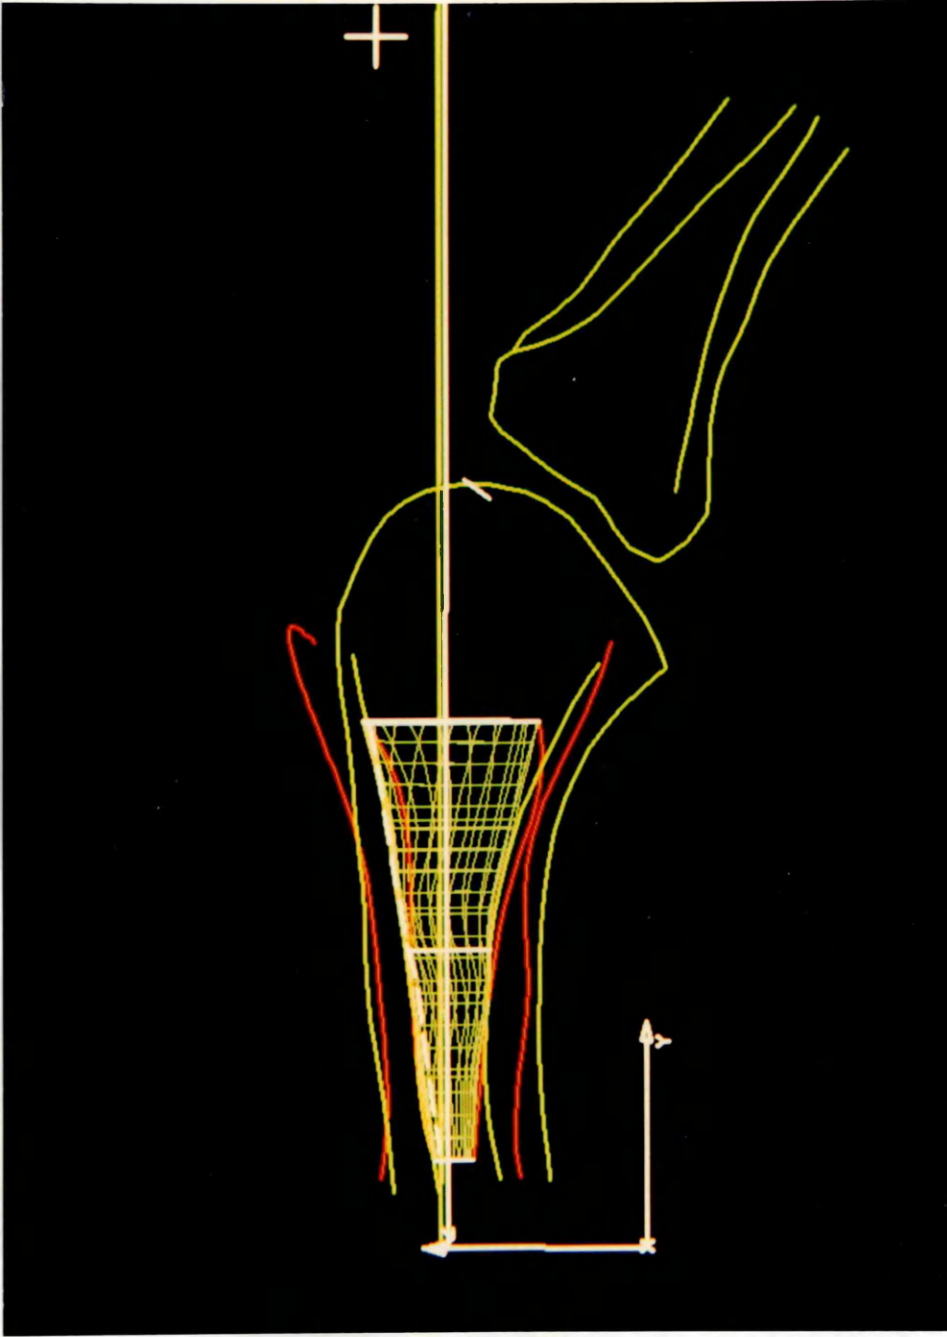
X-ray contour and sections used for modelling before being modified
